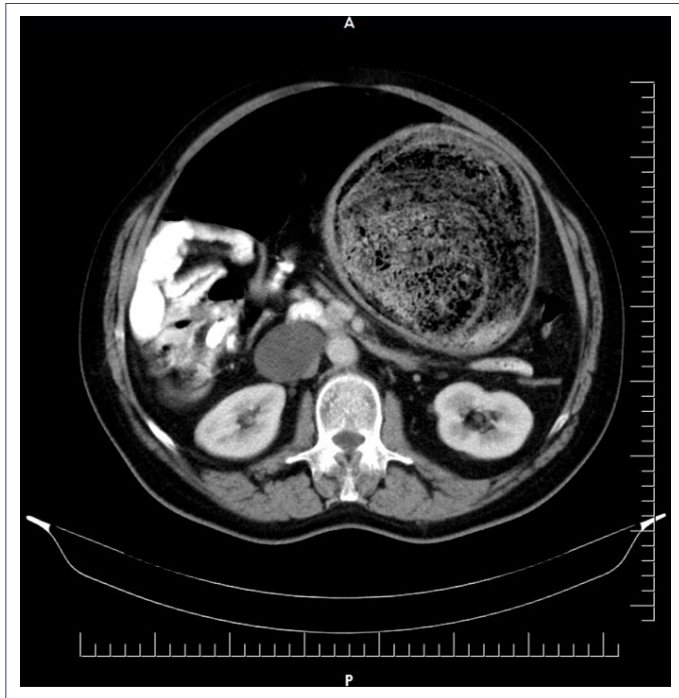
Abdominal computed tomography revealed a solid mass with air bubbles filling the stomach.
